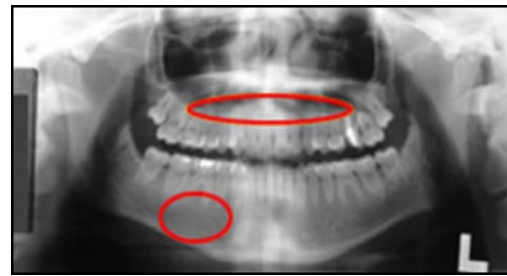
Regions on a panoramic radiograph to look at to determine adequate density.
